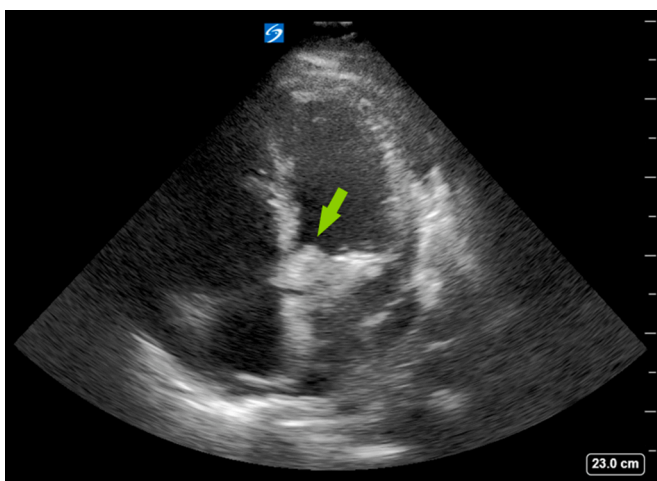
Apical 4 chamber view demonstrating aortic valvular mass.
